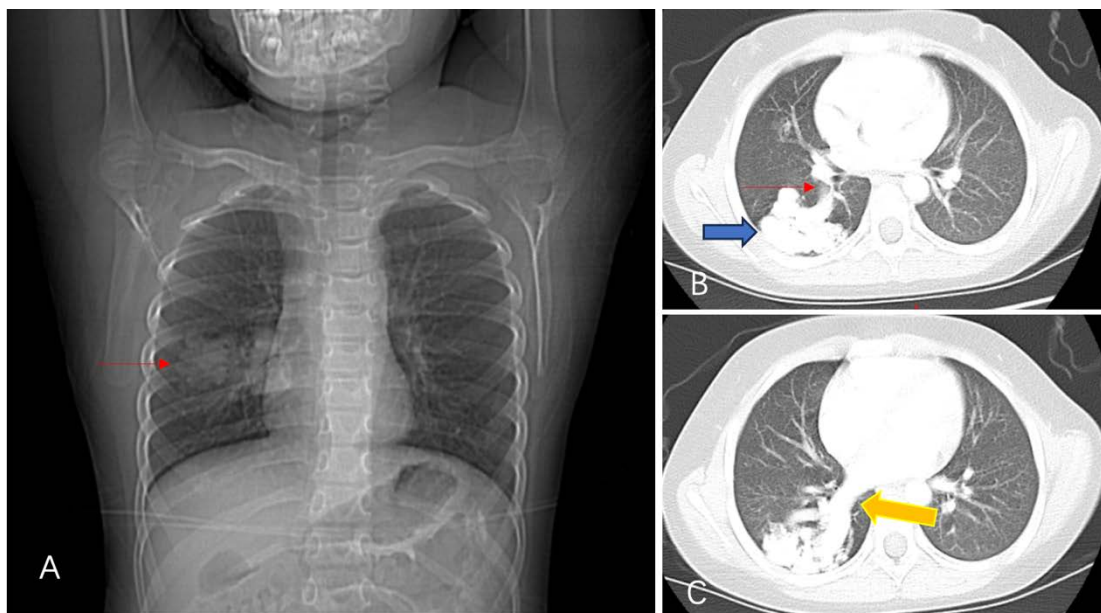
Chest Contrast-enhanced CT: A. substantial increase in mass was observed in the dorsal region of the lower lobe of the right lung, with the lesion measuring around 47*30*36 mm. B. The feeding artery originated as a branch of the pulmonary artery, and separation was observed within the cystic cavity. C. The right lower pulmonary vein exhibits thickening of the draining vein.
